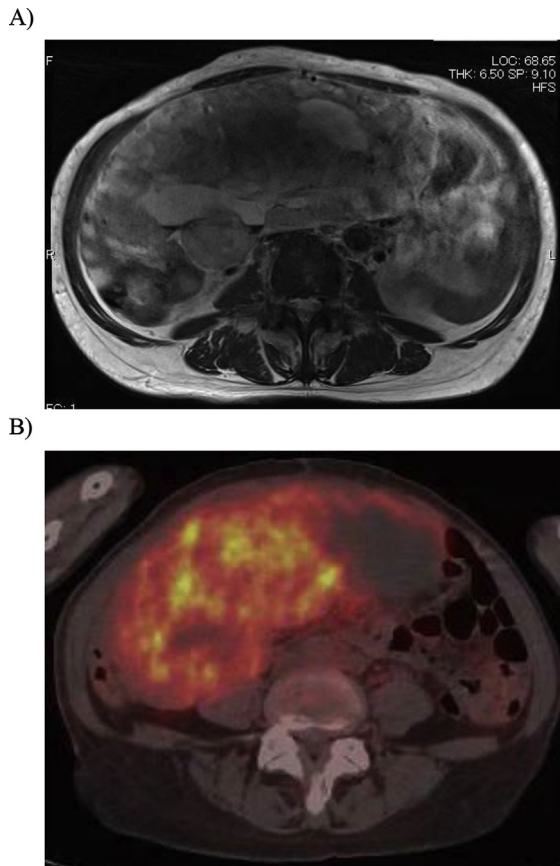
A 57-year-old woman with leiomyosarcoma. (A) On the axial T2-weighted MRI, a heterogeneous, high intensity lesion plus low-intensity lesions were noted. (B) An axial PET/CT image showed intense FDG uptake (SUVmax, 16).
